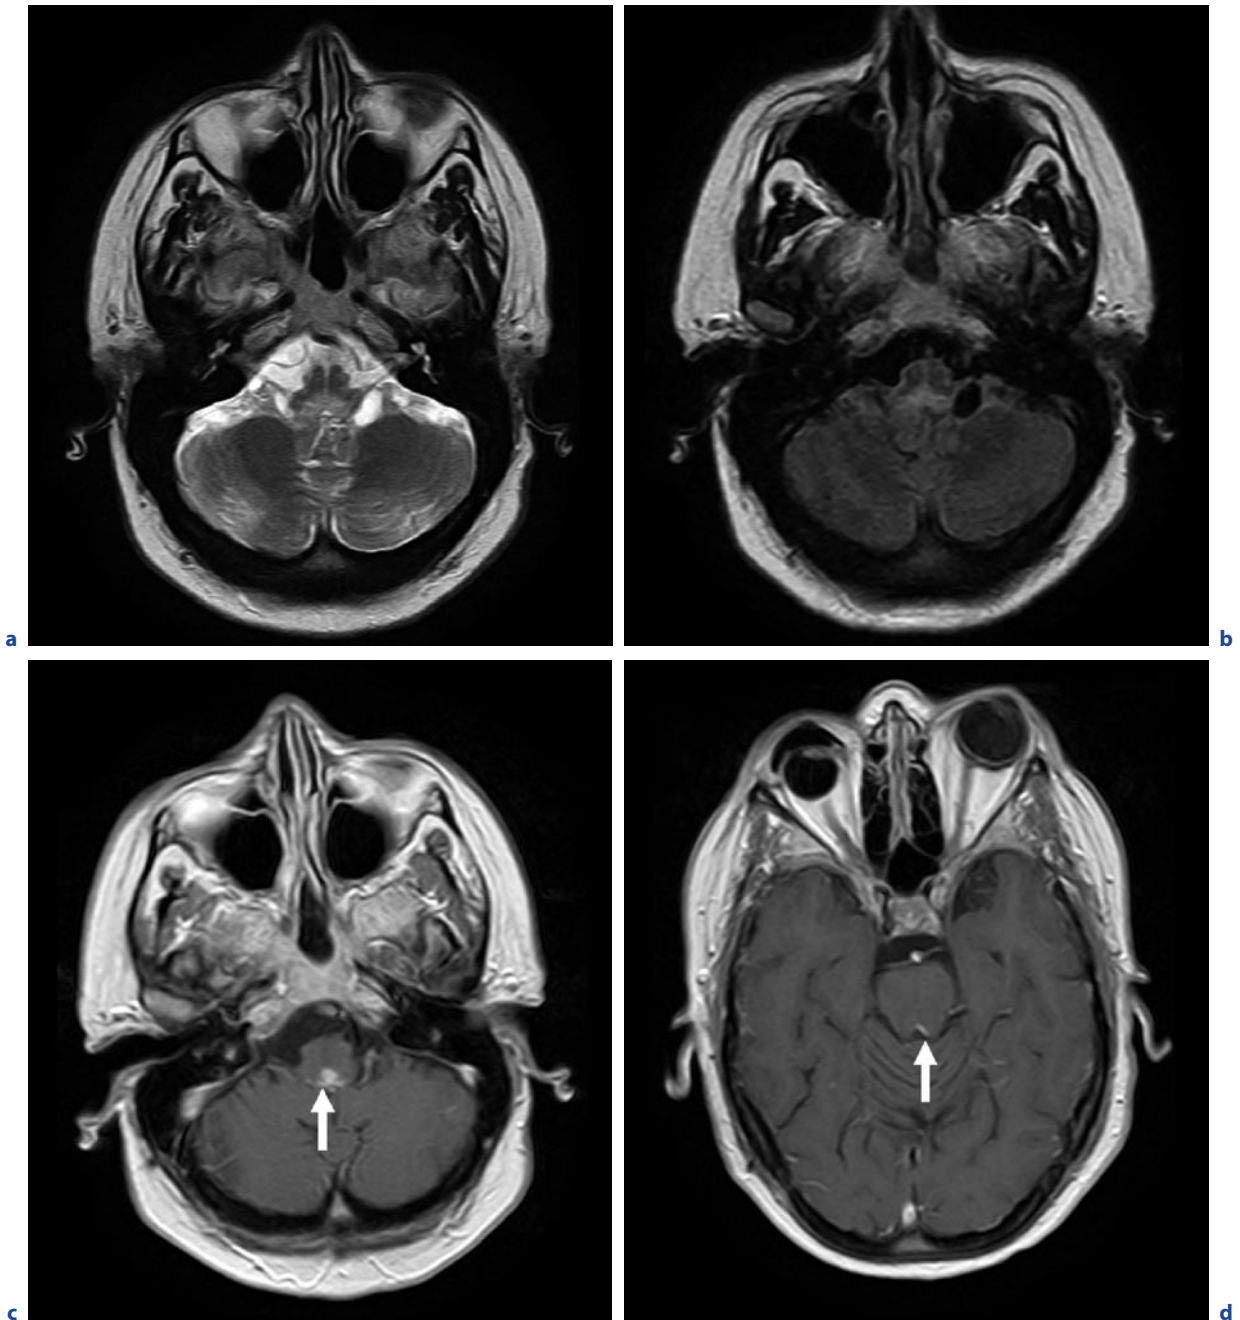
Typical manifestations of neurosarcoidosis. a Axial T2-weighted image. b Axial FLAIR image. c,d Axial T1-weighted image after contrast administration. Enhancing granulomatous tissue in the fourth ventricle (c, arrow) and the adjacent parenchyma of the medulla oblongata with high signal
